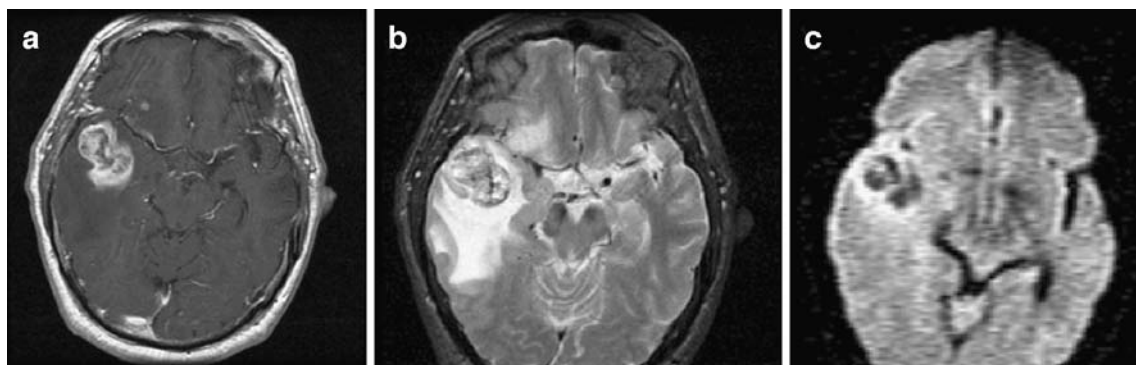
a Glioma (glioblastoma multiforme) with ring-enhancement on T1-weighted MR imaging with gadolinium. b On T2-weighted MR imaging, this glioma demonstrates a peripheral arc of hypointensity, seen medially. The center of the lesion is heterogeneous on this MR sequence. c DW imaging shows a mixed signal
